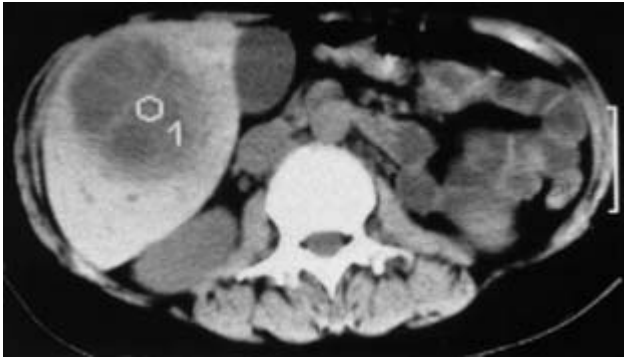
Thalassaemic Greek patient post-splenectomy. CT scan shows a filling defect in the right lobe of the liver with marker over it (labelled 1).
